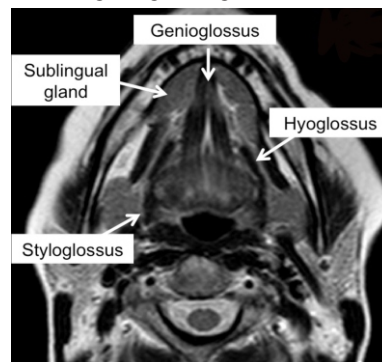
MRI imaging showing clear depiction of extrinsic muscles of tongue
